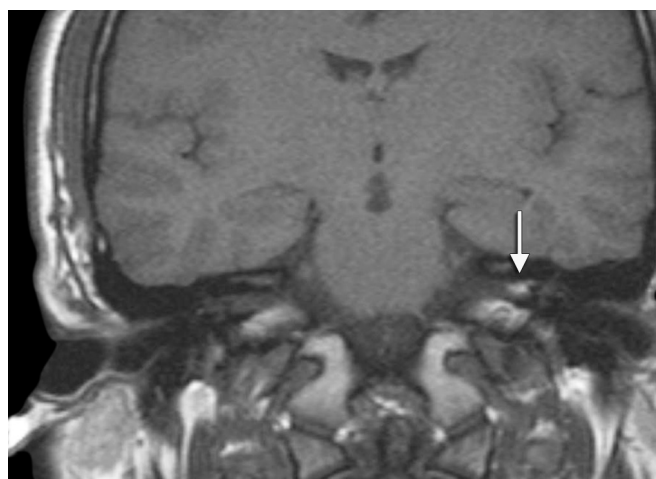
Lipoma of the internal auditory canal. Axial T1-weighted precontrast magnetic resonance imaging (MRI) image with white arrow indicating lesion. Note that unlike most other cerebellopontine angle (CPA) pathology, this lesion is hyperintense on gadolinium T1 images.
